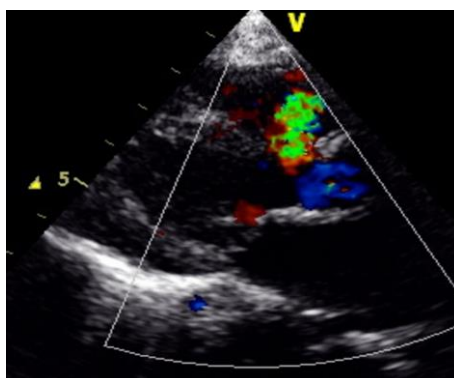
Echocardiogram In Parasternal Long Axis View Showing Perimembranous VSD With Colour Flow Demonstrating Left To Right Shunt.
